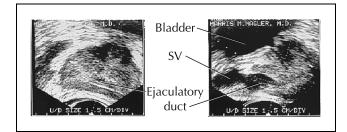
Sagittal (*left*) and longitudinal (*right*) transrectal ultrasonographic images of a patient with ejaculatory duct obstruction. SV—seminal vesicle.
